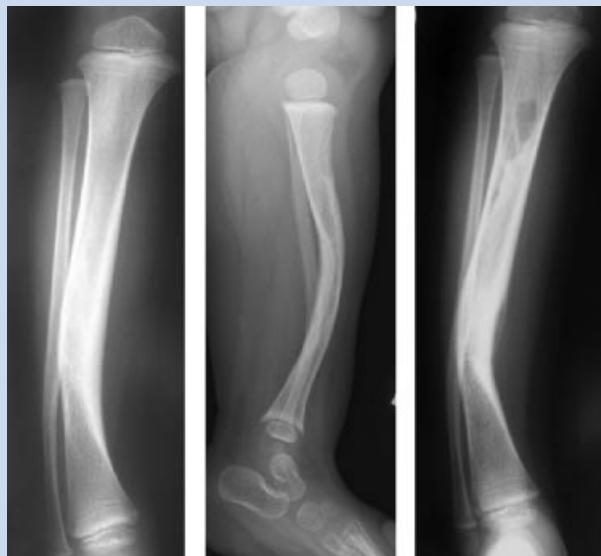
Radiographs of the lower limb of individuals with NF1 with anterolateral bowing of the leg showing cortical thickening near the apex of the bowing with narrowing of the medullary canals.
